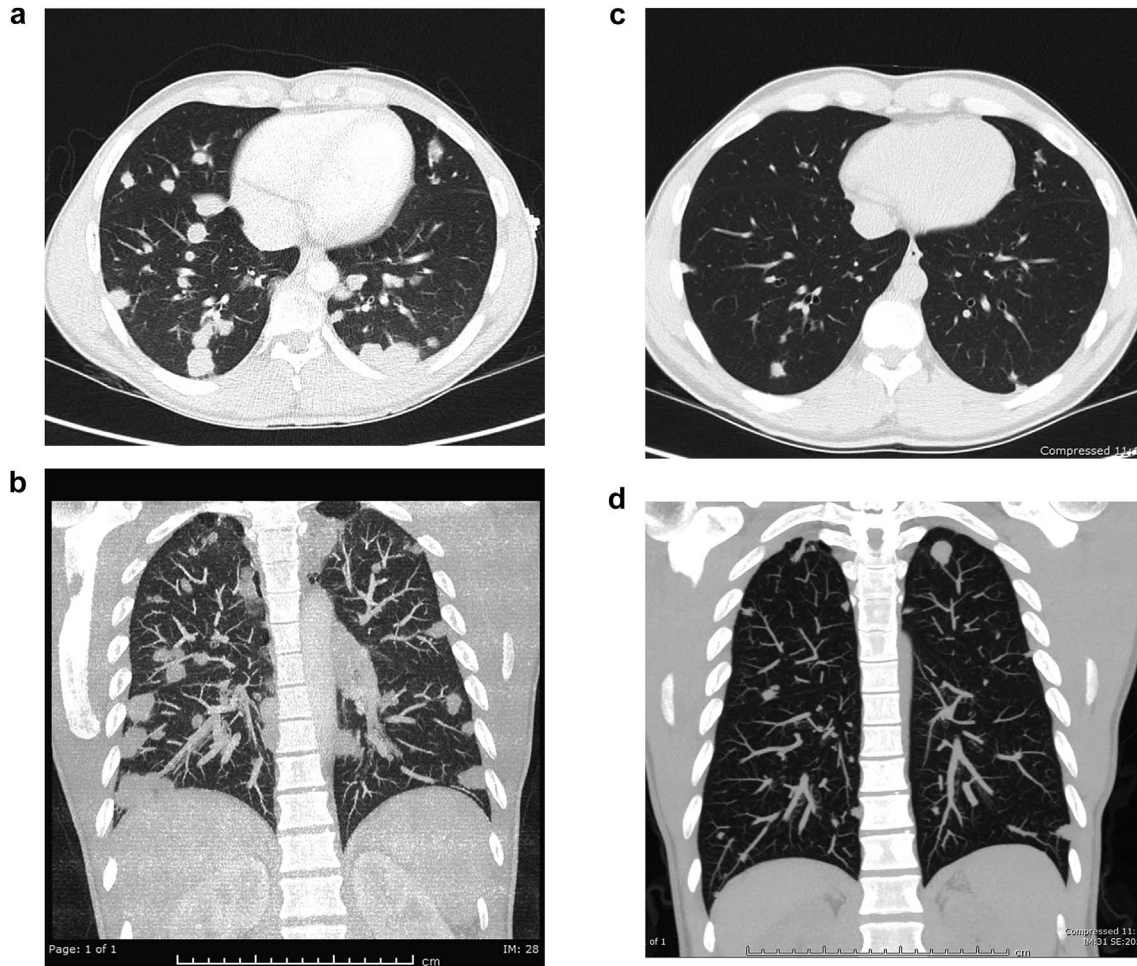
CT chest at presentation (Fig. 1a and b) showing numerous, bilateral lung nodules of varying size and CT chest after 15 weeks of treatment (Fig. 1c and d) showing significant reduction in the size and number of pulmonary lesions, but not yet complete resolution.
